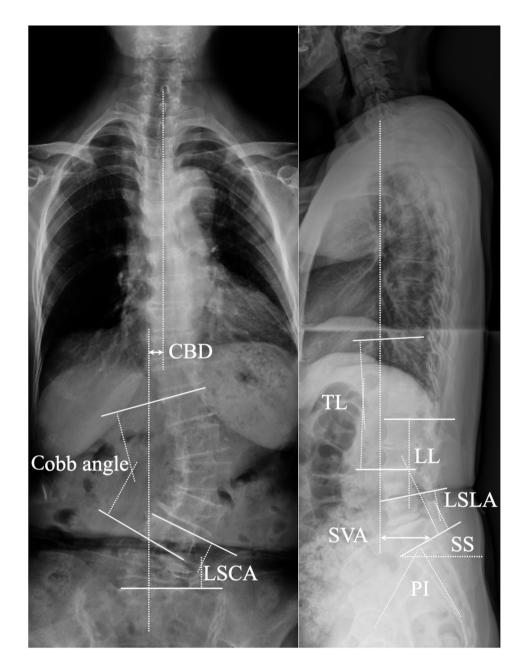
The radiological data measured on the P/A X-ray include Cobb's angle, lumbosacral coronal angle (LSCA) and coronal balance distance (CBD). The radiological data measured on the P/A X-ray include lumbar lordosis (LL), thoracolumbar junction (TL), pelvic incidence (PI), sacral slope (SS) and sagittal vertical axis (SVA)
